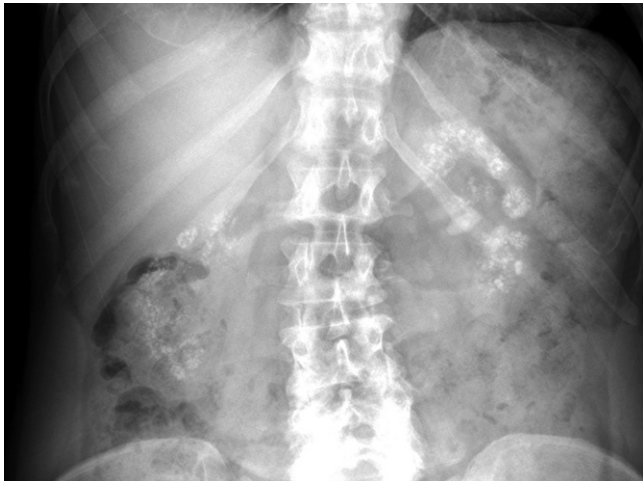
Abdomen radiographs demonstrating bilateral renal calcifications outlining the renal pyramids, consistent with medullary nephrocalcinosis.
